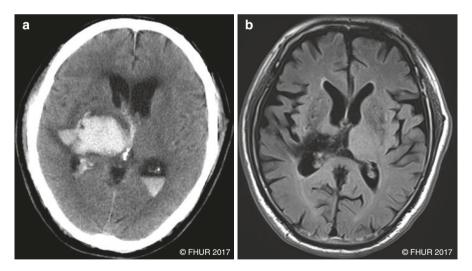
(a) Axial CT scan of the brain at the time of hemorrhage onset. The large area of increased density (white) represents acute bleeding in the right thalamic area, and the low density surrounding the blood indicates adjacent cerebral edema. (b) Axial fluid-attenuated inversion recovery magnetic resonance image at the time of admission to the rehabilitation ward shows hypointensity involving the right thalamic area
